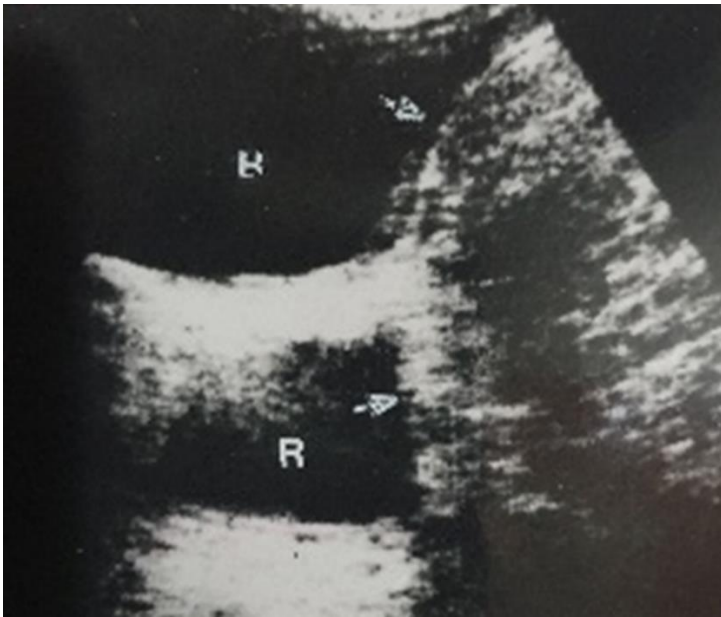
Ultrasound showing a retro-vesical mass mimicking an “enlarged prostate”.
